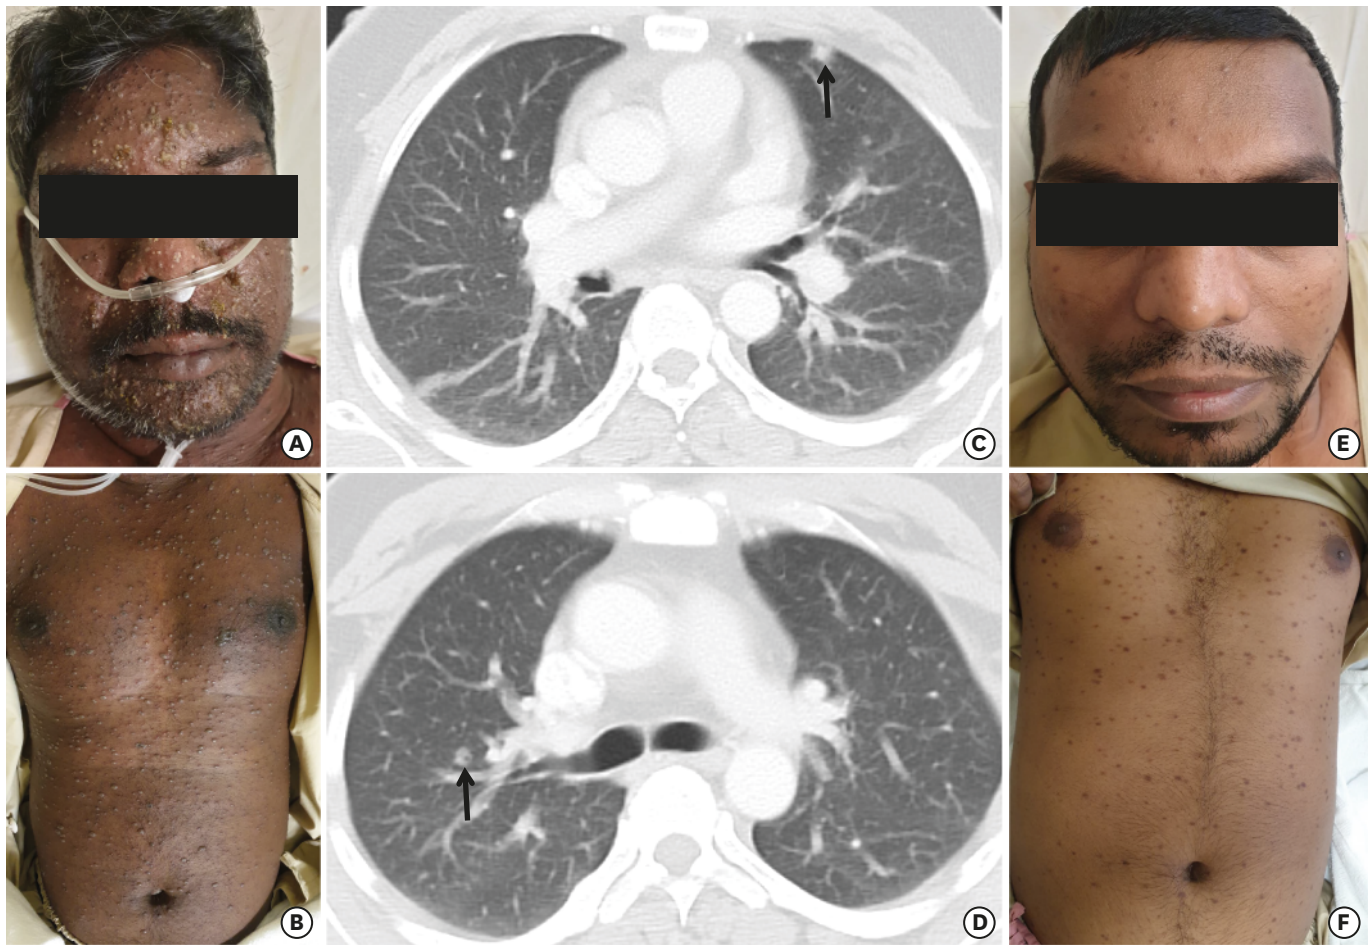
Clinical Features of Patients with Varicella and COVID-19 Co-infections. (A) Clinical Photograph, Patient 1, Vesicular rash on face. (B) Clinical Photograph, Patient 1, Vesicular rash on trunk. (C) Computed Tomography Thorax, Patient 1. (D) Computed Tomography Thorax, Patient 1. (E) Clinical Photograph, Patient 3, Papulo-vesicular rash on face. (F) Clinical Photograph, Patient 3, Papulo-vesicular rash on trunk.
